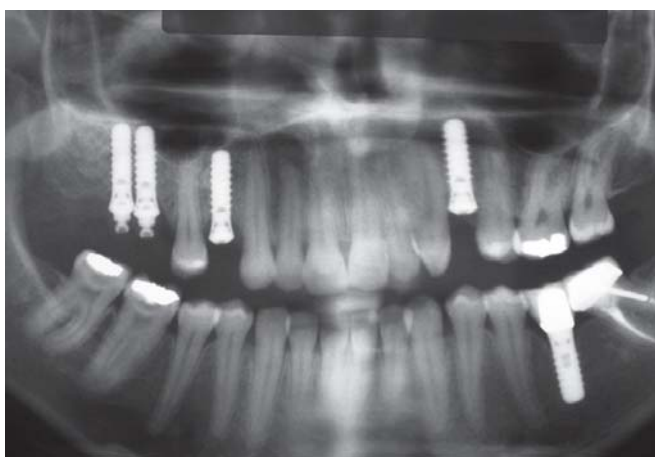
Panoramic radiographs 3 months after surgery for the right maxillary site demonstrating stable peri-implant condition
